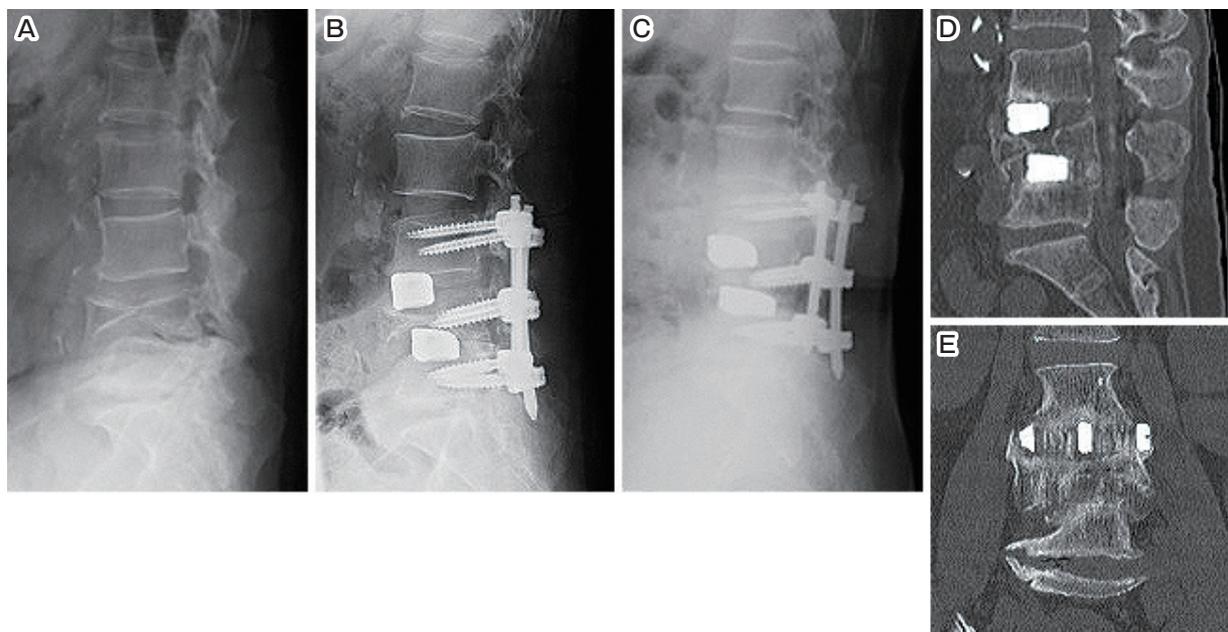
Plain radiography and CT scans of a 66-year-old female with bi-concave L4 vertebral fracture.
